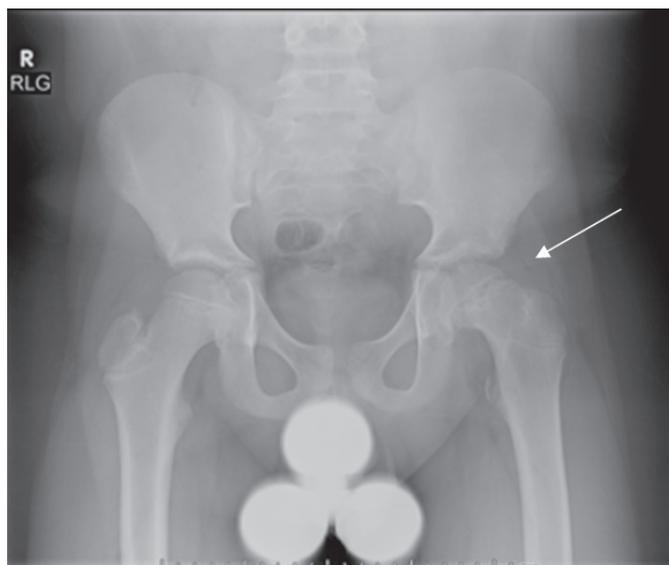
Varus slipped capital femoral epiphysis located on the left femur. The image depicts a plain X-ray of the pelvis prior to in situ pinning of the left hip. (Case 1)
